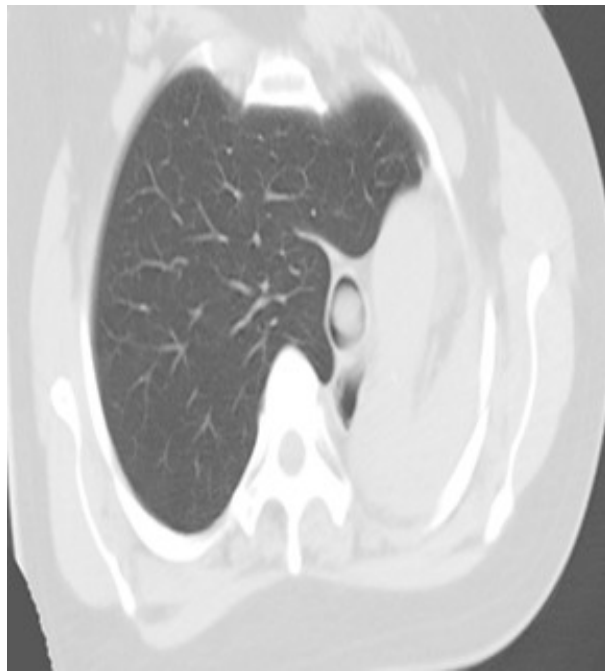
CT thorax showing intraluminal mass and collapse of left lung with hyperinflation of right lung
